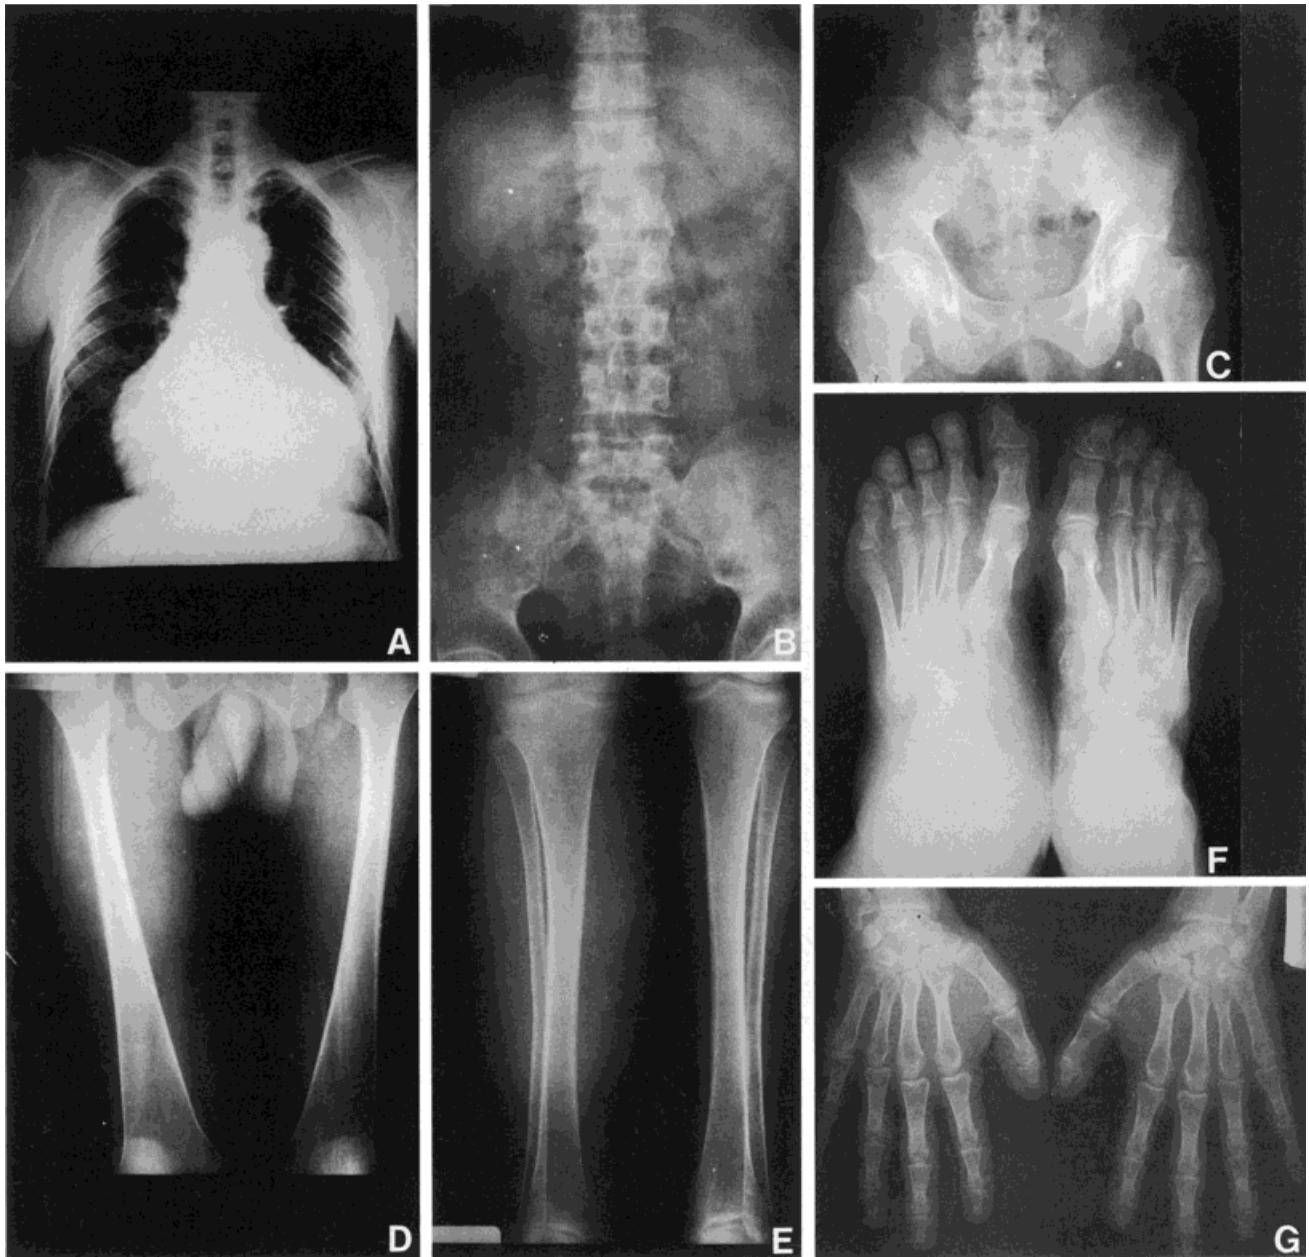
Patient E, X-ray photographs at 35 years. A: Narrow thorax and pericarditis with effusion. B: Platyspondyly, cuboid vertebral bodies. C: Hypoplastic ischiopubic branches, small obturator foramen, bilateral coxa valga. D, E: Long bones with "Erlenmeyer-flask" appearance with broad medullary canals. F: Broadened first metatarsals with short and broad distal phalanx. G: Short distal phalanx of the thumbs.
